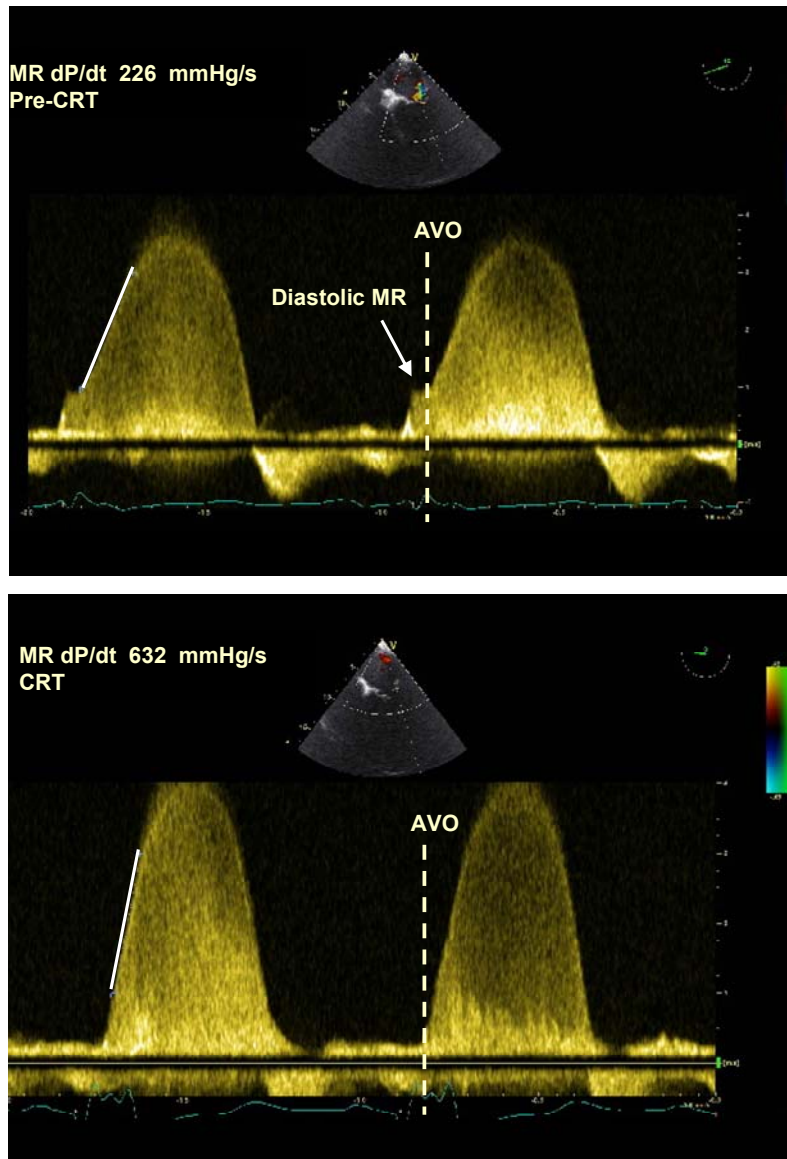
Significant improvement of dP/dt values derived from the mitral regurgitation trace (MR) before (top) and immediately after CRT device implantation, obtained by transesophageal echocardiography. Furthermore, pre-systolic MR present before biventricular pacing as a consequence of a long atrioventricular delay (top, arrow) is resolved by CRT (bottom).
